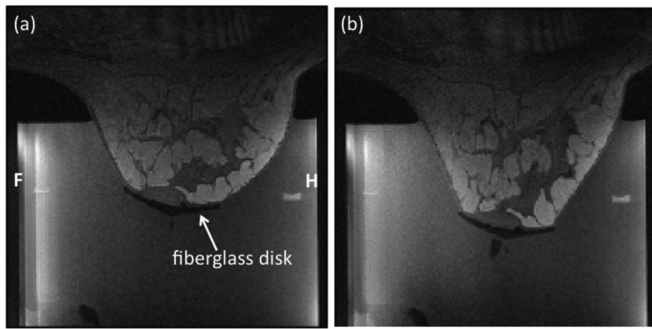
Sagittal MRI images of a normal volunteer with the breast (a) suspended freely in the water-filled treatment cylinder and (b) with mild vertical tension applied. The patient is positioned head first, prone in the bore. Head (H) and foot (F) orientations are labeled in (a). Images were obtained using the 11-channel integrated RF coil array. The field of view is 183×183 mm.
